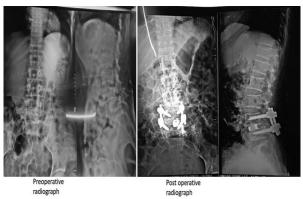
Preoperative and postoperative radiographs of case 2, showing transforaminal interbody fusion
